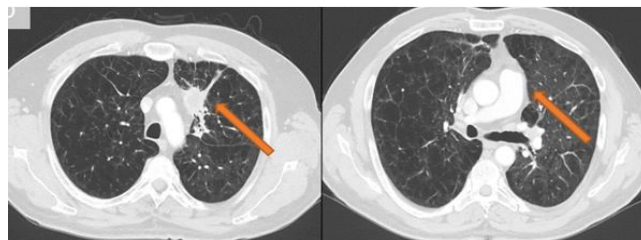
Chest CT at 6-month follow-up in which the former nodular lesion in the right upper lobe is no longer visible and significant regression can be seen in the lesion in the left upper lobe
